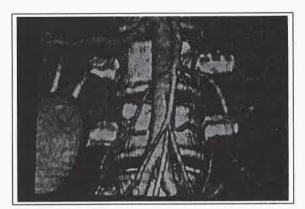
CT angiography in bilateral renal artery stenoses. VR (a), SSD (b), and MIP (c) images, inferior oblique view. Due to inappropriate levels of threshold and filtration, the right renal artery appears occluded in the SSD image, while the MIP and VR images dislocate the patent lumen.
